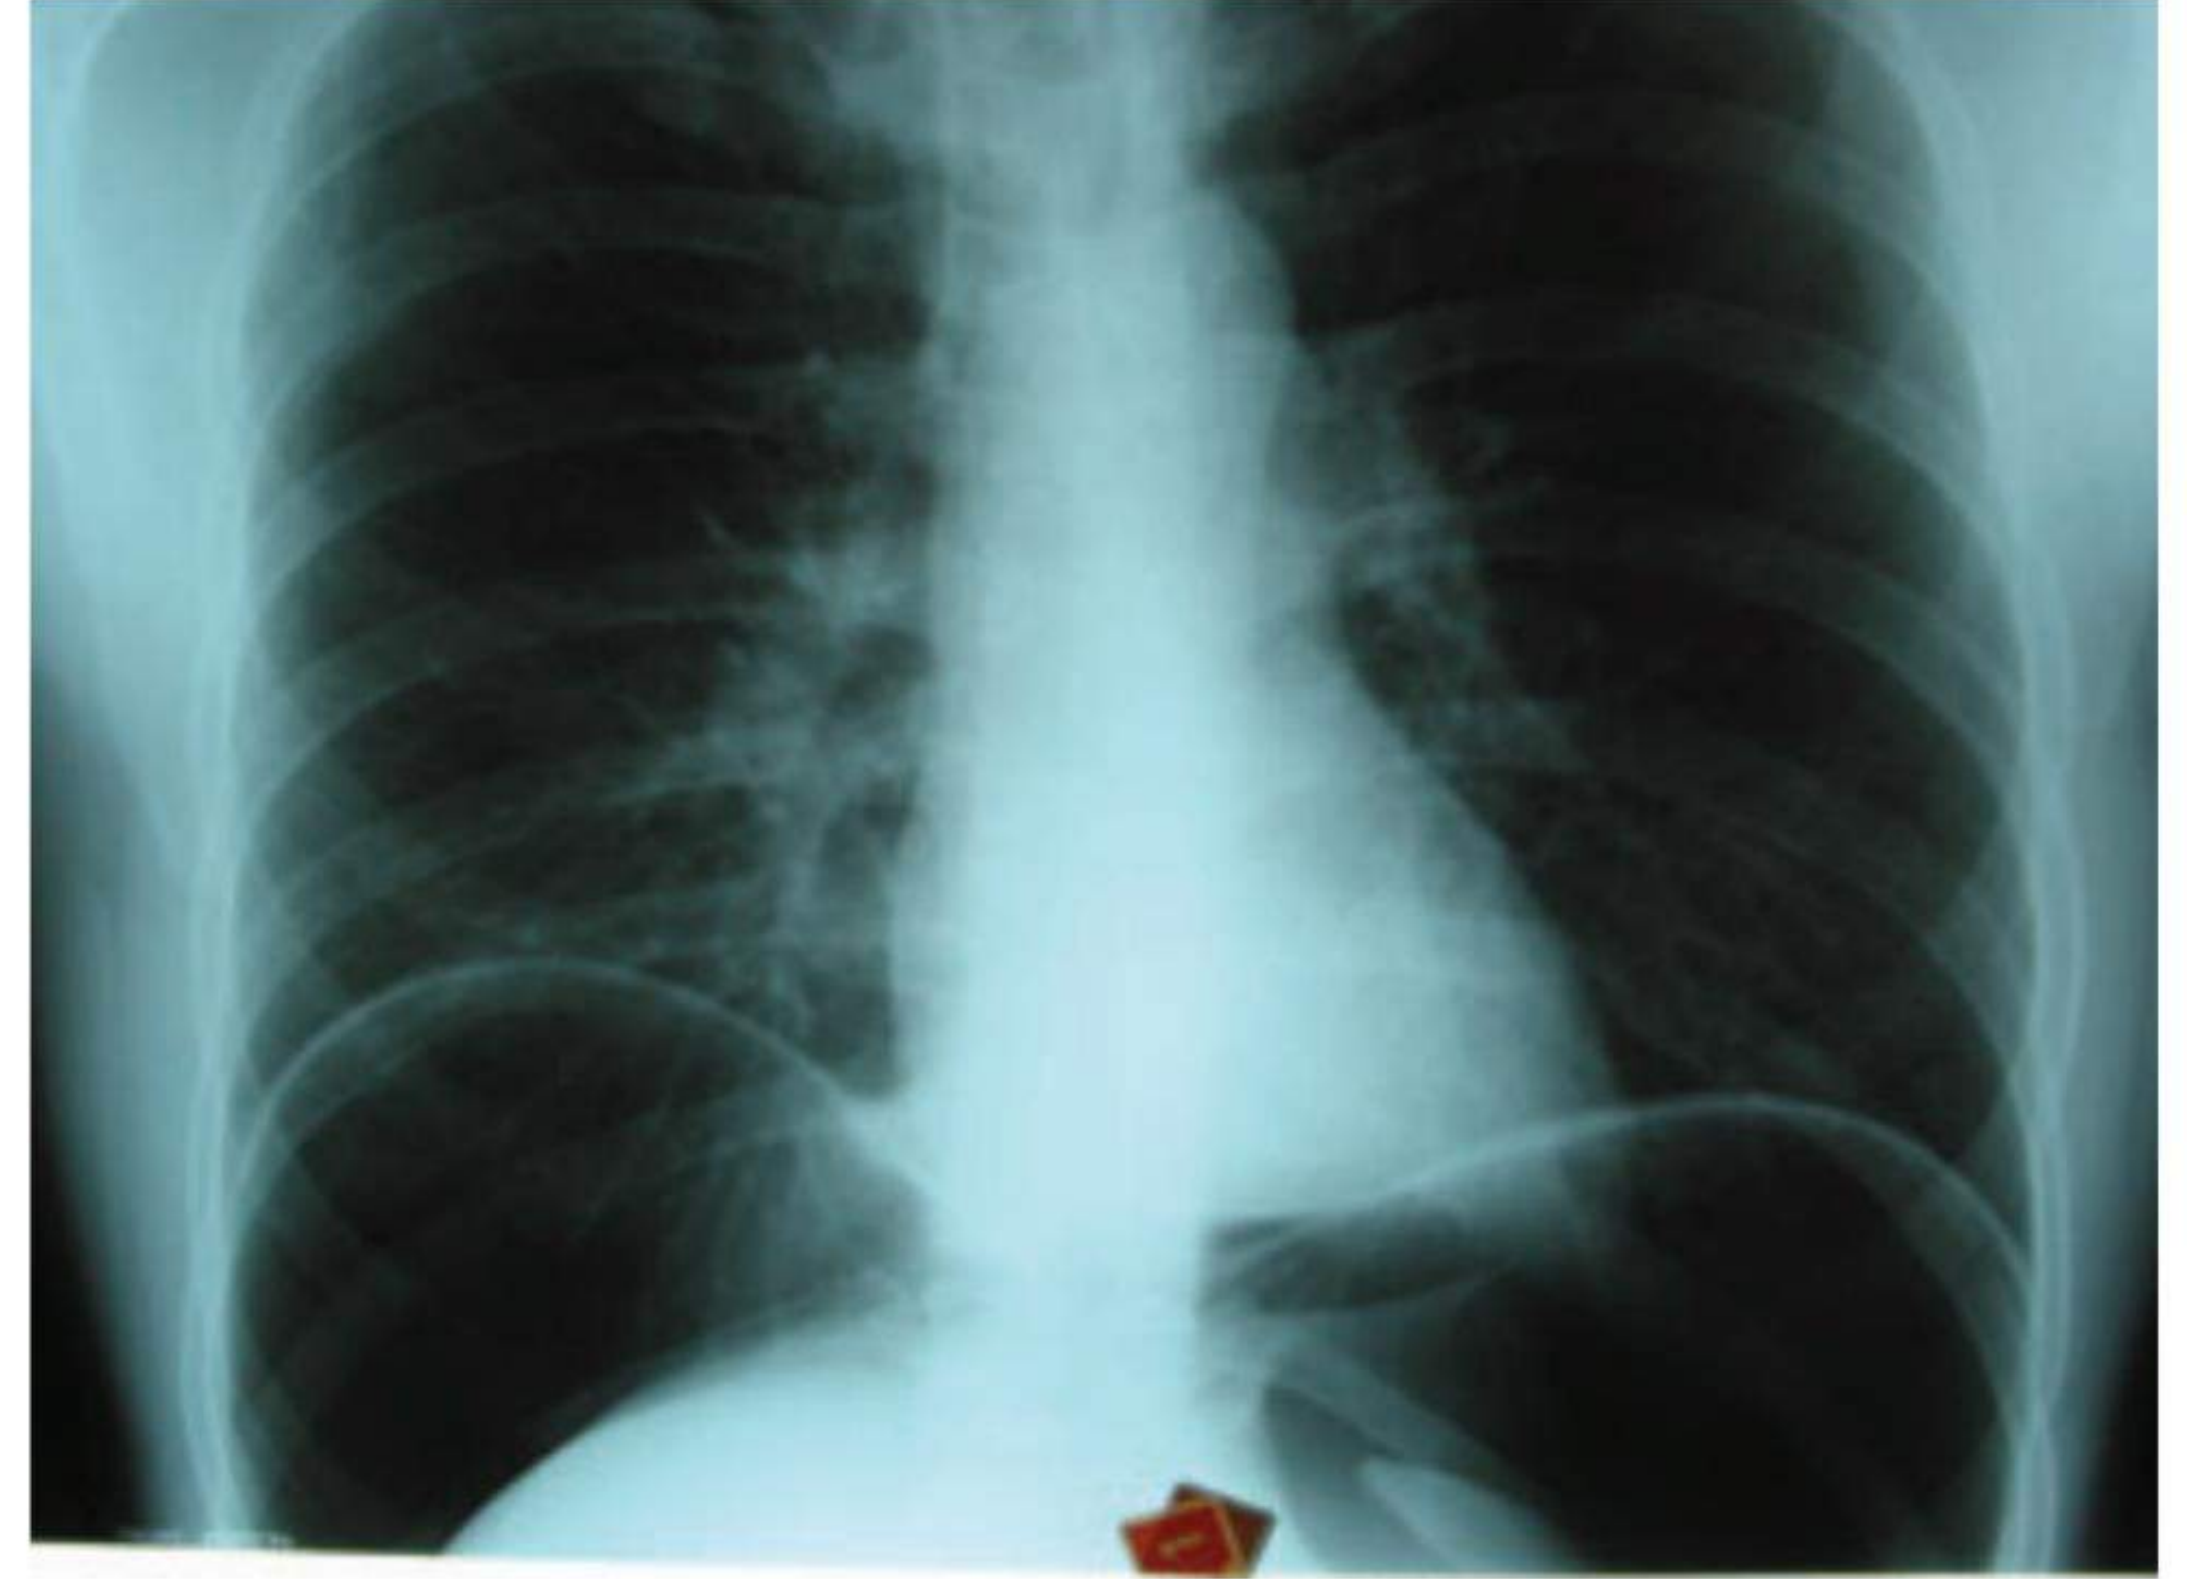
Erect chest X-ray showing free air under both hemidiaphragms, following iatrogenic colonic perforation at rigid sigmoidoscopy.
